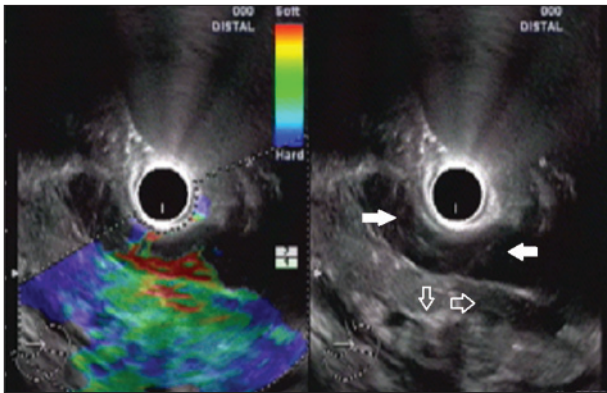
Endoscopic ultrasound (EUS) in necrotizing pancreatitis: mixed hyperechoic and hypoechoic areas (open arrows). Peripancreatic echogenicity, soft on EUS elastography, suggestive of EPN also seen (bold arrows)
